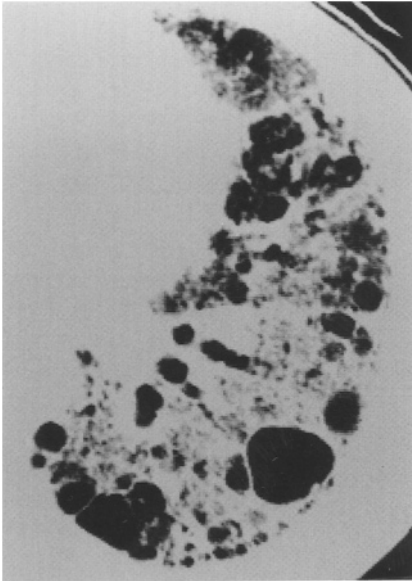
HRCT scan of hard metal pneumoconiosis. Multilobular consolidation with bullae and traction bronchiectasis and bronchiolectasis is seen
